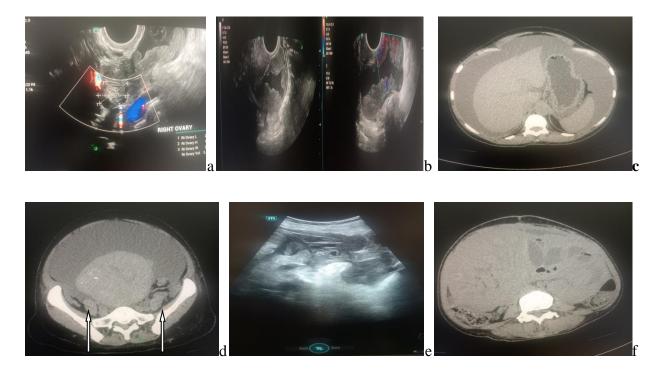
Imaging: Ultrasound scan showing (a) normal right ovary (b) enlarged left ovary with nodular wall & mixed echogenicity and increased vascularity on Doppler interrogation
